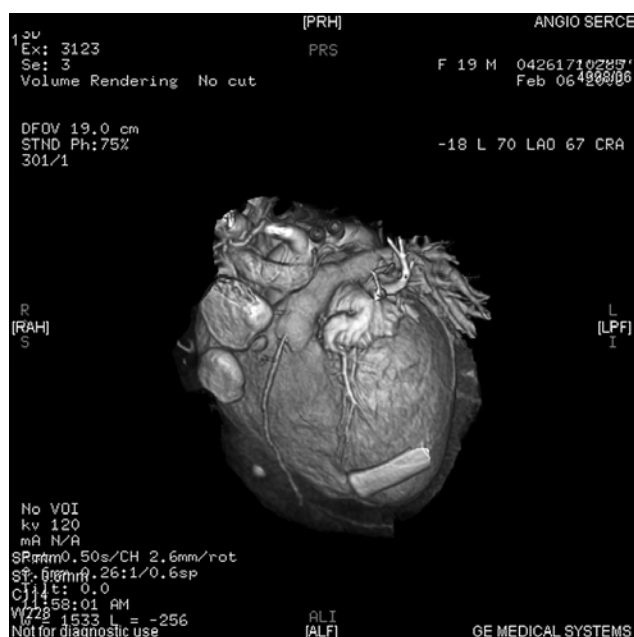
Angio-CT scan that shows pathologically elongated and dilated LAA with lacunar peripheral segments and hypertrophied lacunar walls
